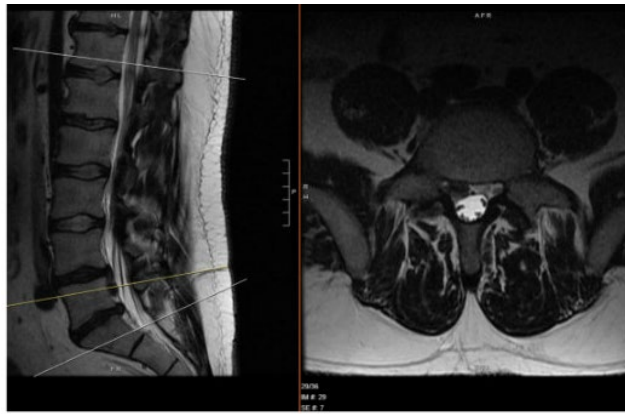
MRI of Patients Lumbar Spine Noting Discs Herniations, Stenosing, and Abnormal Contrast Enhancement of Multiple Cauda Equina Roots.
